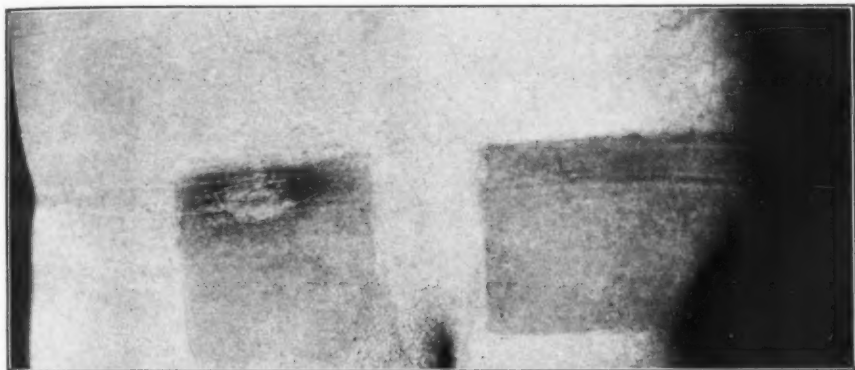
Stronger reaction after X-ray treatment of skin area corresponding to the position of a truss (thin atrophic skin). Skin also much changed over an area corresponding to the truss-pad (dose 1 S. E. D.).
